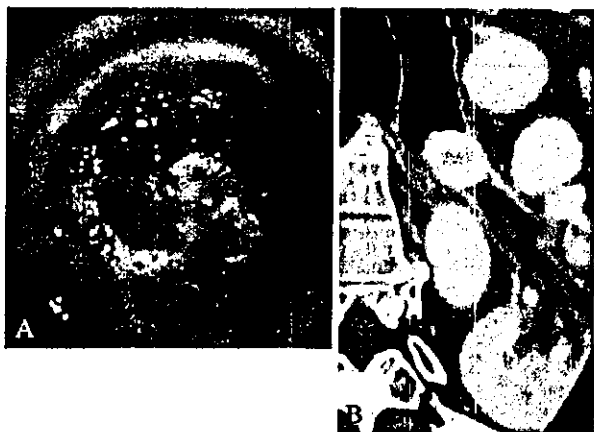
This patient (case 7) had complete atelectasis of the left whole lung. Bronchoscopy shows a polypoid lesion, which almost completely occluded the left main bronchus (A). Chest CT on the coronal view shows a well-circumscribed enhanced mass with occlusion of left main bronchus (B).
